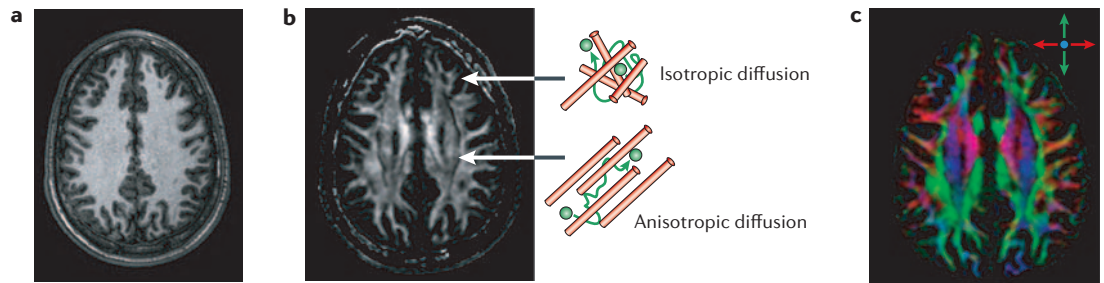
Comparison of a conventional T1-weighted image and DTI-based contrasts. These images show the same slice level from the same subject. a | The T1-weighted image shows the detailed anatomy of the cortex but the white matter appears homogeneous. b | The anisotropy map shows the regions that have high diffusion anisotropy, a hallmark of axonal fibres with a coherent orientation within a pixel. c | For high anisotropy regions, we can map the fibre orientation using colours. In this map, red, green and blue represent fibres running along the right–left, anterior–posterior and superior–inferior axes, respectively. Fibres running along oblique angles are represented by a mixture of the three principal colours.
